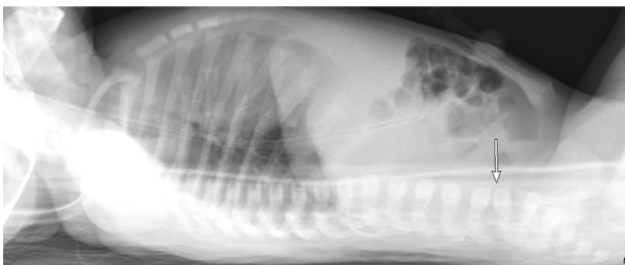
Lateral radiograph of the chest and abdomen demonstrating the vertebral anomaly at L4-L5 (white arrow).
